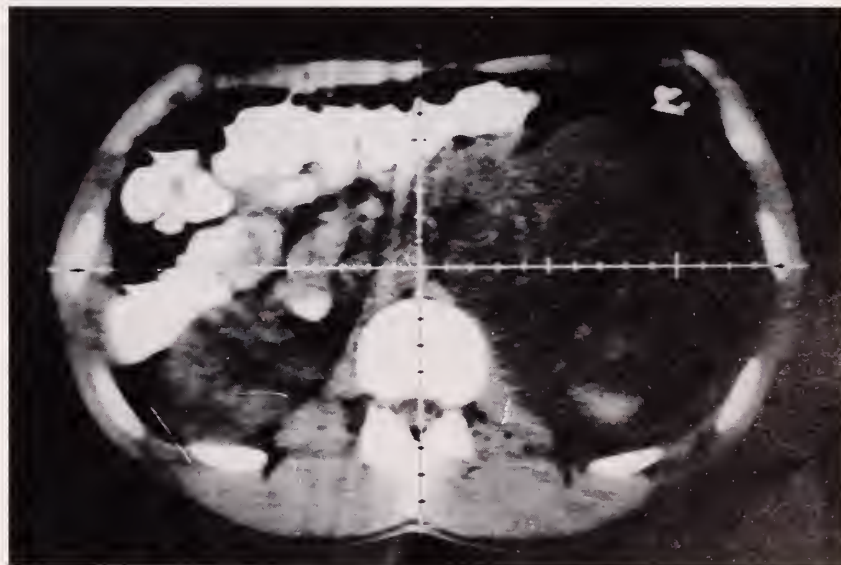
CT scan of the abdomen showing a large left-sided renal mass.
